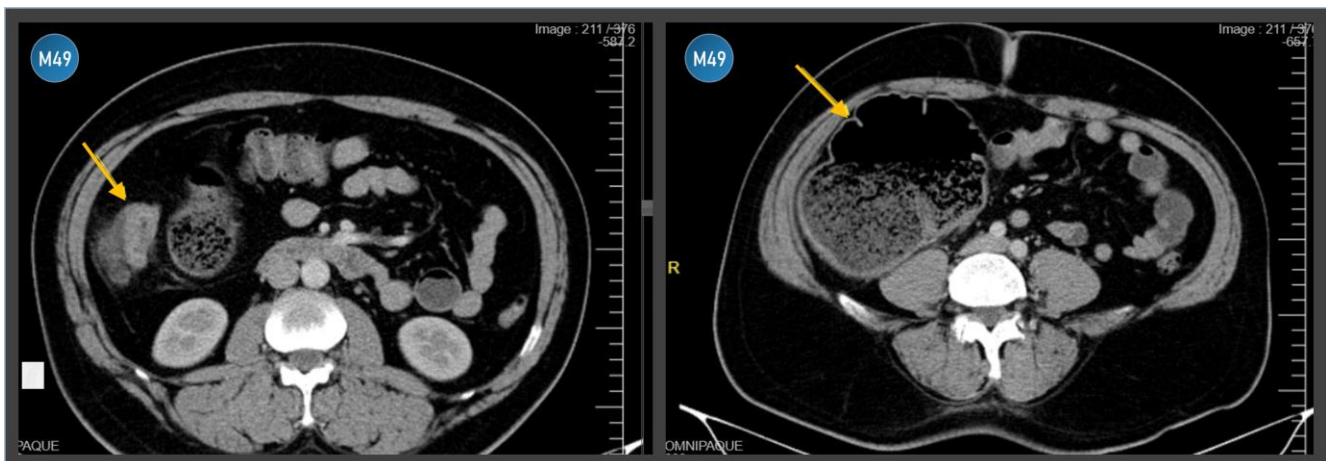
Radiologic imaging findings a patient (gender/age) had low titer HIV reactive serologic results. M49 (abdominal computed tomography); Tumoral mass in the ascending colon and dilatation of the cecum.
